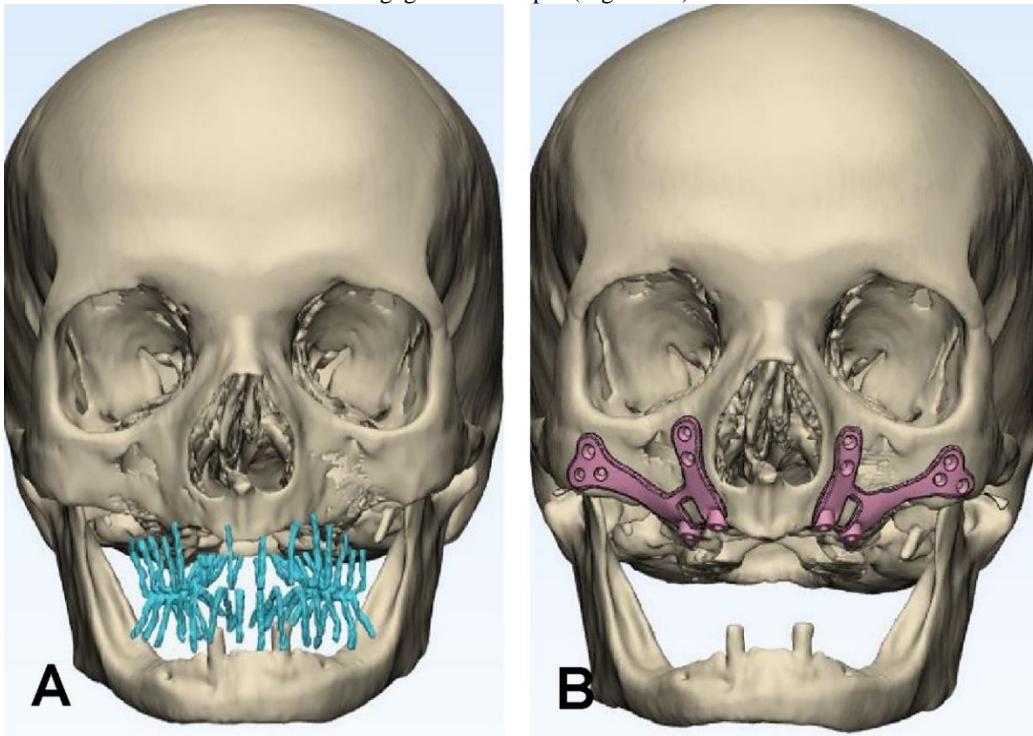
A) CT scan with marker; B) Design of subperiosteal implant
